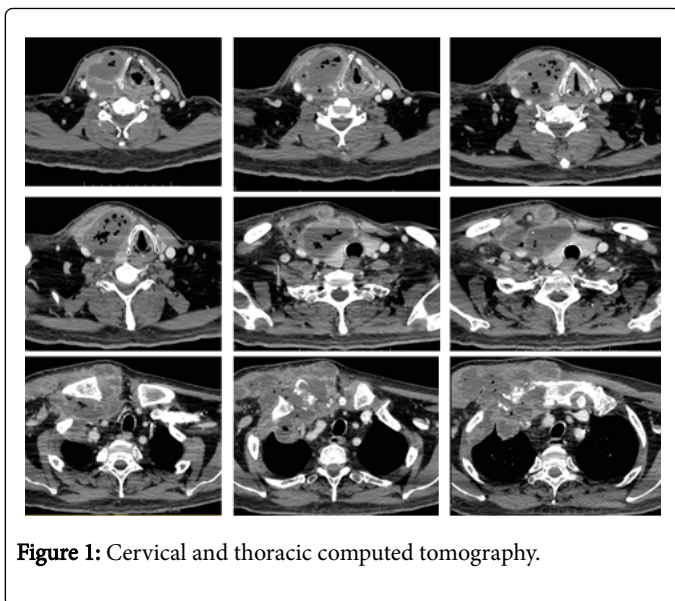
Cervical and thoracic computed tomography.
